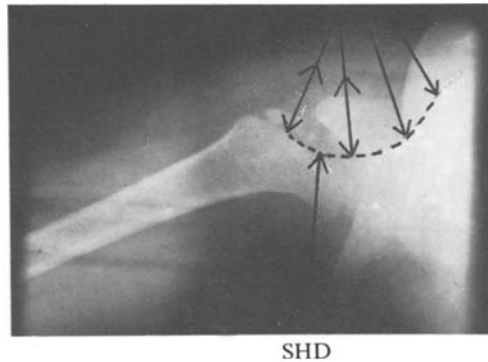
Radiograph in position analogous to Fig. 12a. Ultrasonic beam marked by arrows, SHD-line: femoral neck–ilium line
